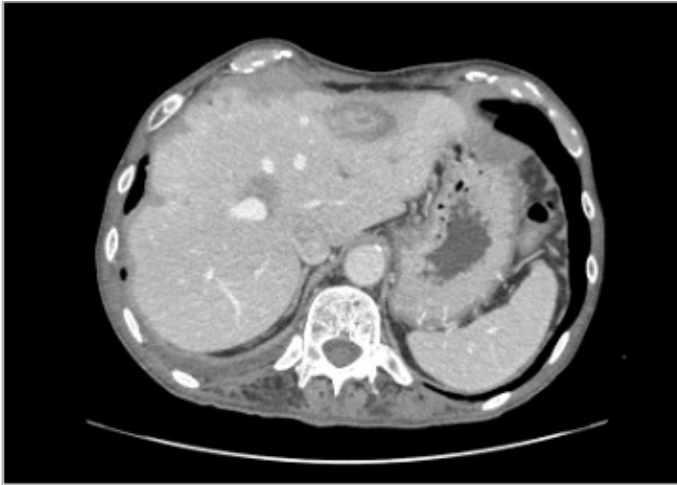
Multiple hypodense-necrotic lesions at the contrast-enhanced abdominal CT scan.
